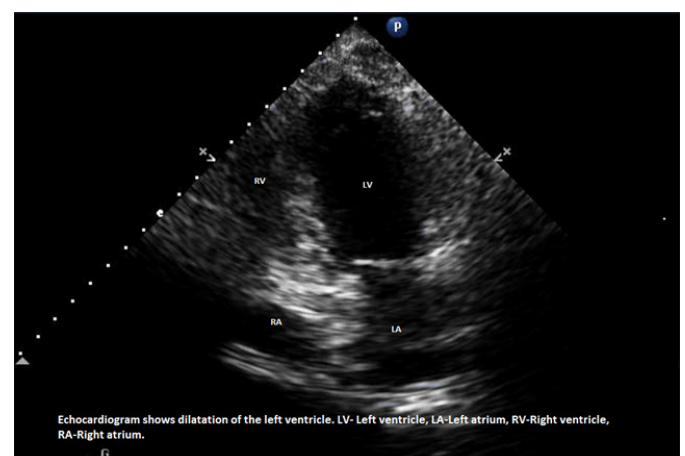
Echocardiogram.
